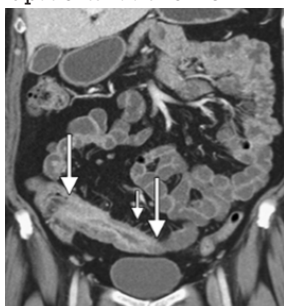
CT enterography coronal image shows mural thickening with target appearance due to Crohn's disease in terminal ileum (long arrows). Additional findings supporting diagnosis of Crohn's disease include fibrofatty proliferation and prominent vasa recta (short arrow)
